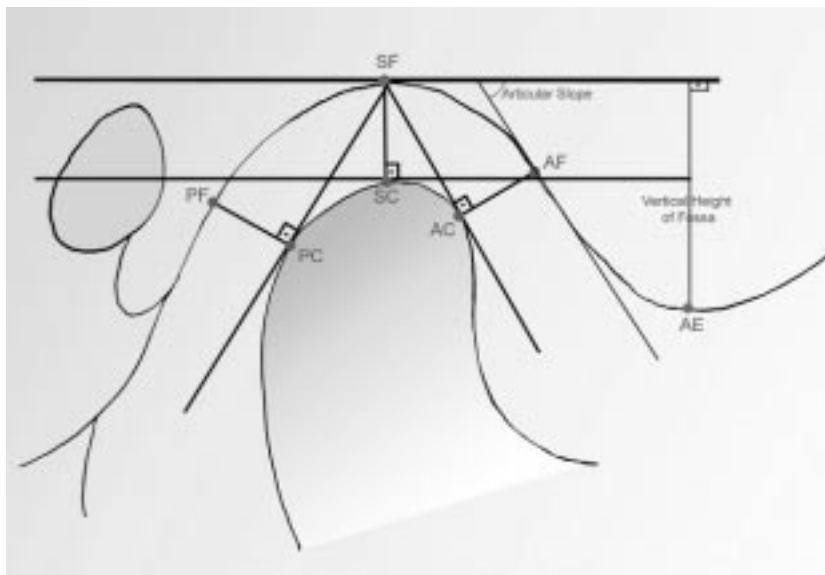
Measurements made on transcranial radiographs.
